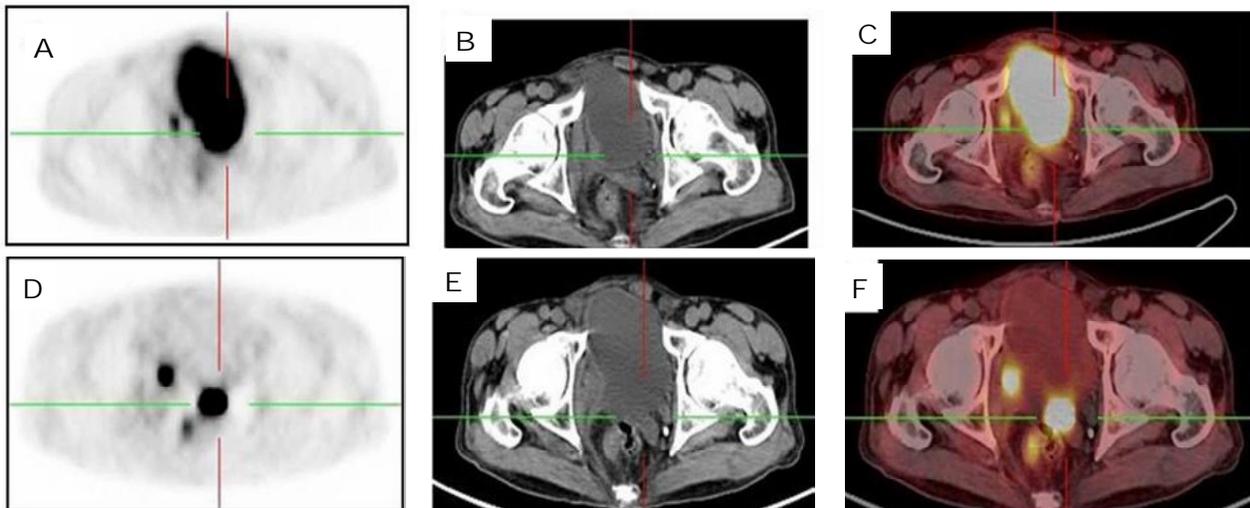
Pre-intervention PET (A), plain CT (B) and PET-CT (C) images. Images do not delineate the tumour. Post-intervention PET (D), plain CT (E) and PET-CT (F) images show clear delineation of tumour.
